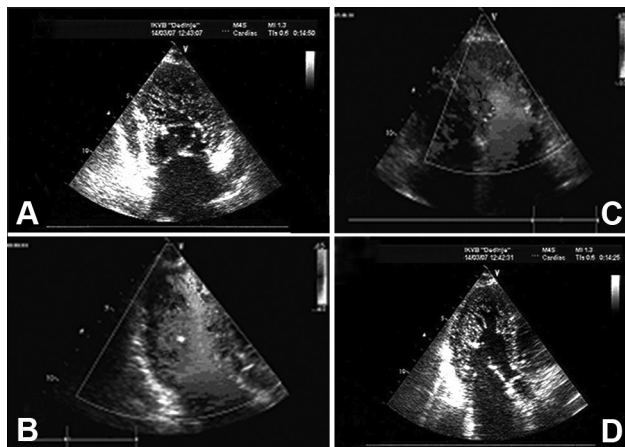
(A, D) Transthoracic two-dimensional echocardiography shows apical two and three chambers view where hypertrabeculation in the apical two thirds of all walls can be seen. (B, C) Color Doppler confirmed that the deep intertrabecular space is in the connection with the left ventricular cavity.
